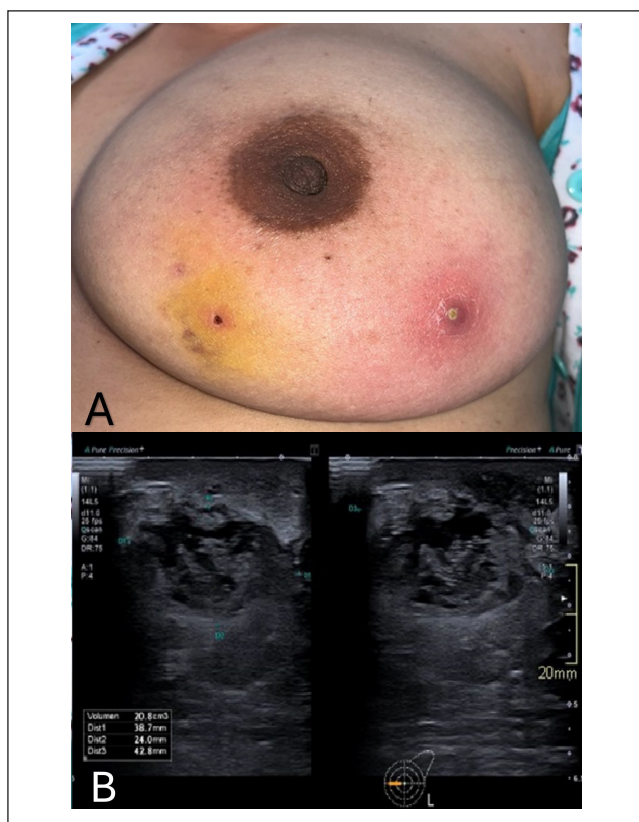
Relevant images for the case. A). Clinical image: Erythematous papules, pustules, and an irregular mass of approximately 5×3 cm in the lower outer quadrant without axillary lymphadenopathy. B). Breast ultrasound: fibroglandular tissue with a predominance of fat component, with a heterogeneous image with a cystic content and mobile echoes in its interior in the interline of the inner quadrants with diameters of $38 \times 24 \times 42$ mm and a volume of 20 cm^3 associated with thickening of the adjacent skin and an isoechoic image to the fatty tissue with diameters of $34 \times 16 \times 31$ mm and a volume of 9.7 cm^3 suggestive of chronic collection.
